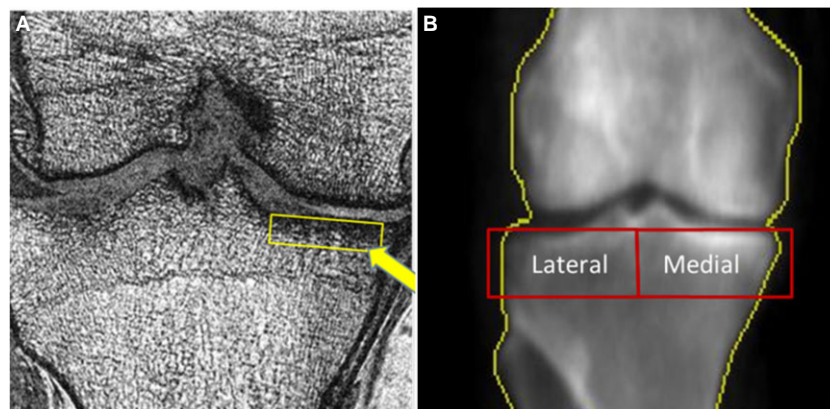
A, Representative trabecular bone sequence–acquired coronal slide. Arrow indicates a region of interest (ROI). B, Representative dual x-ray absorptiometry image of the same knee. Medial and lateral ROIs are shown in red.
